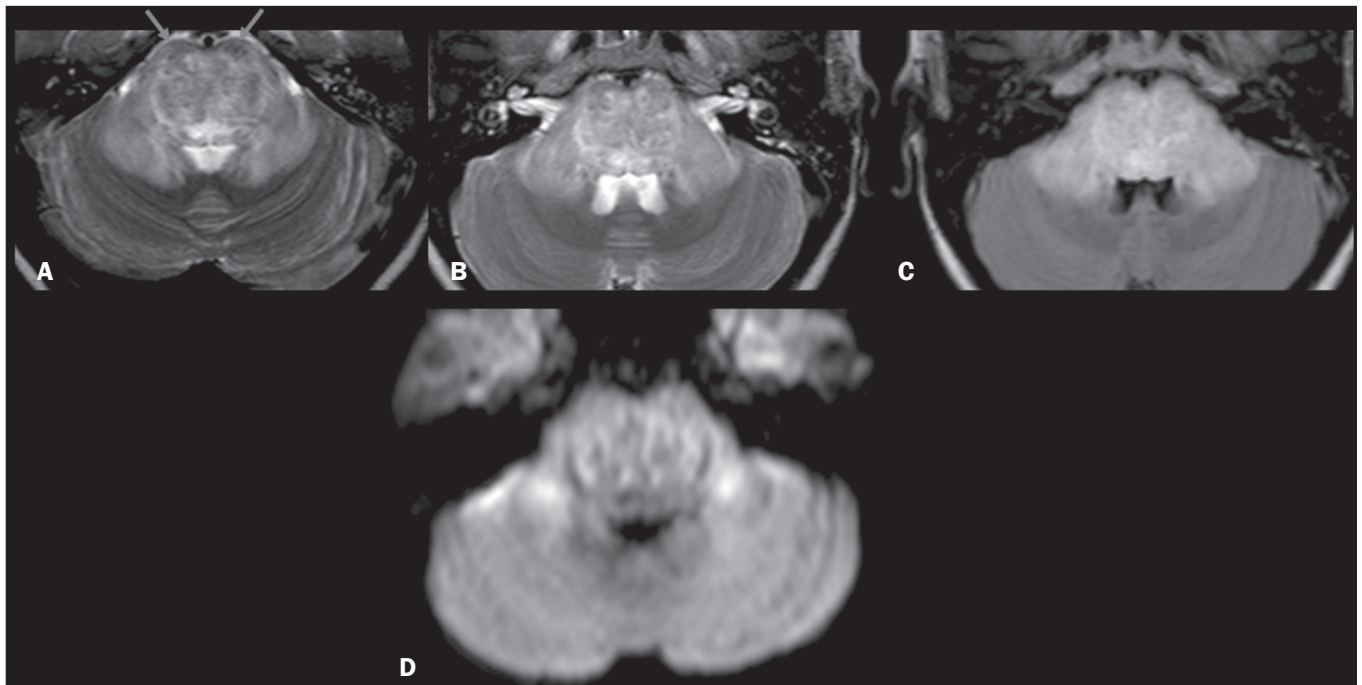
ODS. Axial T2WI (A,B) and axial FLAIR sequence (C), showing confluent hyperintensity involving the pons while sparing its anterior peripheral aspect and extending into the MCPs. D: DWI showing restricted diffusion
